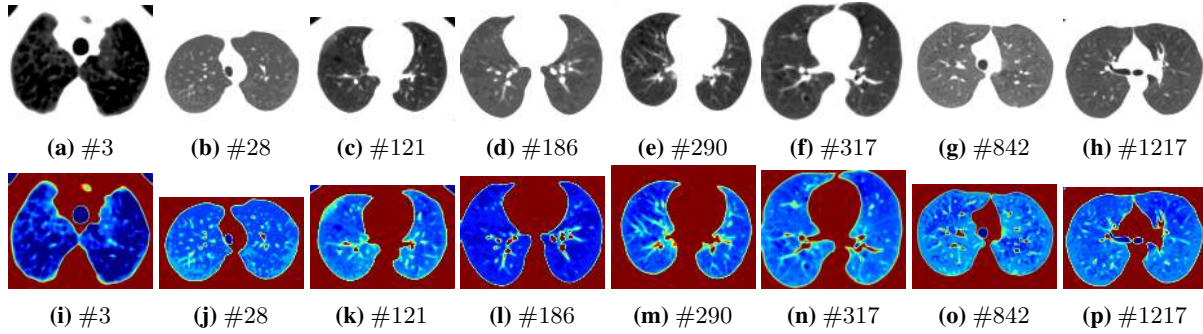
(a – h) PQIS-Net segmented lung CT slices# [29] with COVID-19 infections followed by (i – p) color mapping for class level  $L = 8$  with activation  $\xi$
